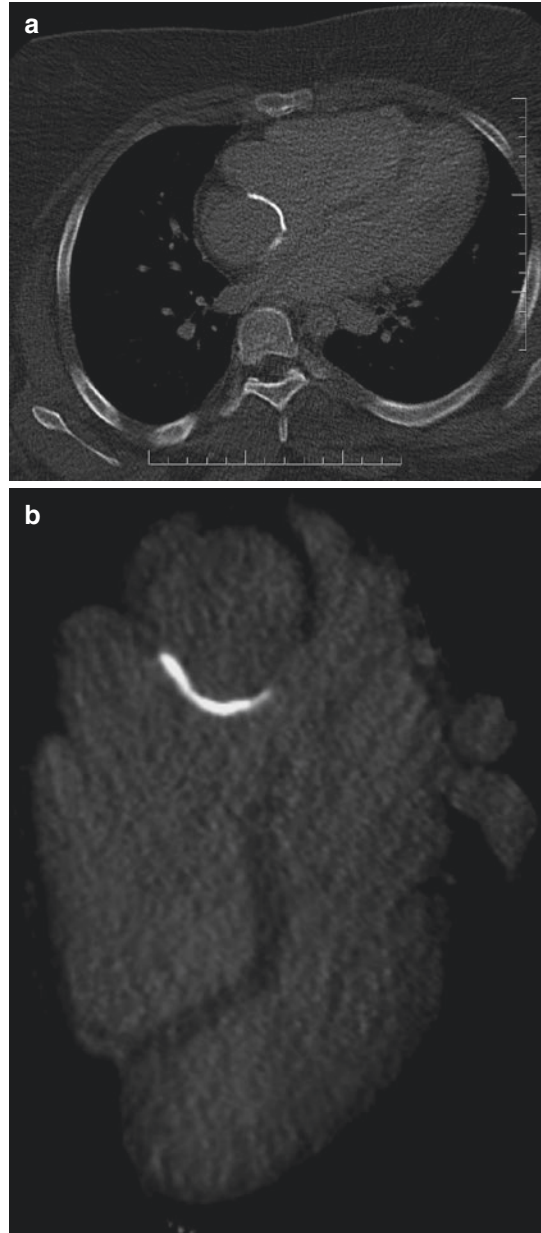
Cardiac CT of a patient with underlying Ebstein anomaly palliated with a lateral tunnel Fontan, now calcified. Axial view (a) and reconstructed four chamber view (b)
